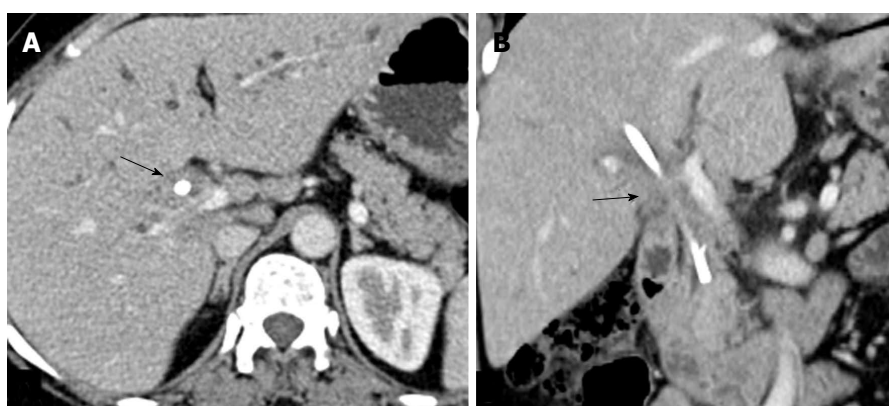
Axial (A) and coronal (B) computed tomography scan of a case of hilar cholangiocarcinoma after endoscopic stenting showing circumferential wall thickening of common hepatic duct around the stent. It would be difficult to differentiate this from reactive thickening.
